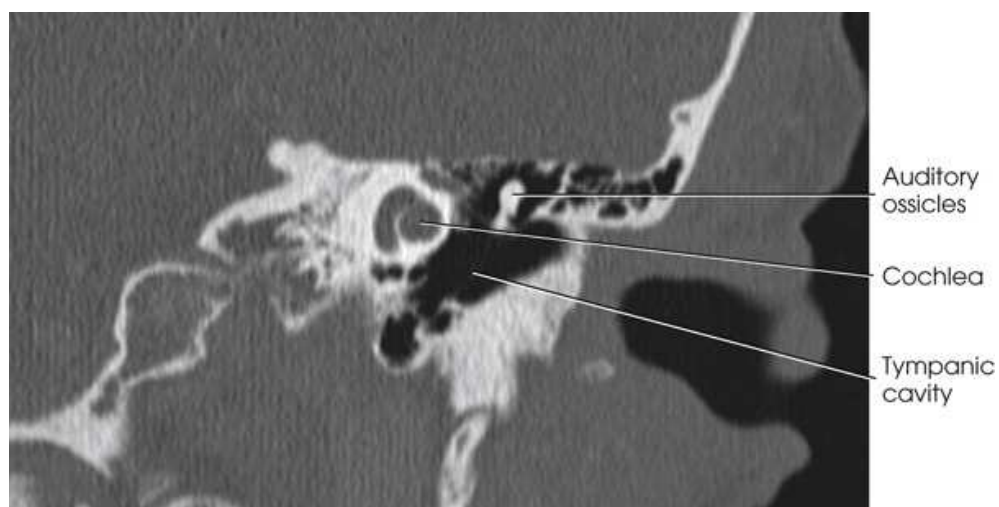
Coronal CT scan through petrous portion of temporal bone showing middle and inner ear. Courtesy Karl Mockler, RT[R].
